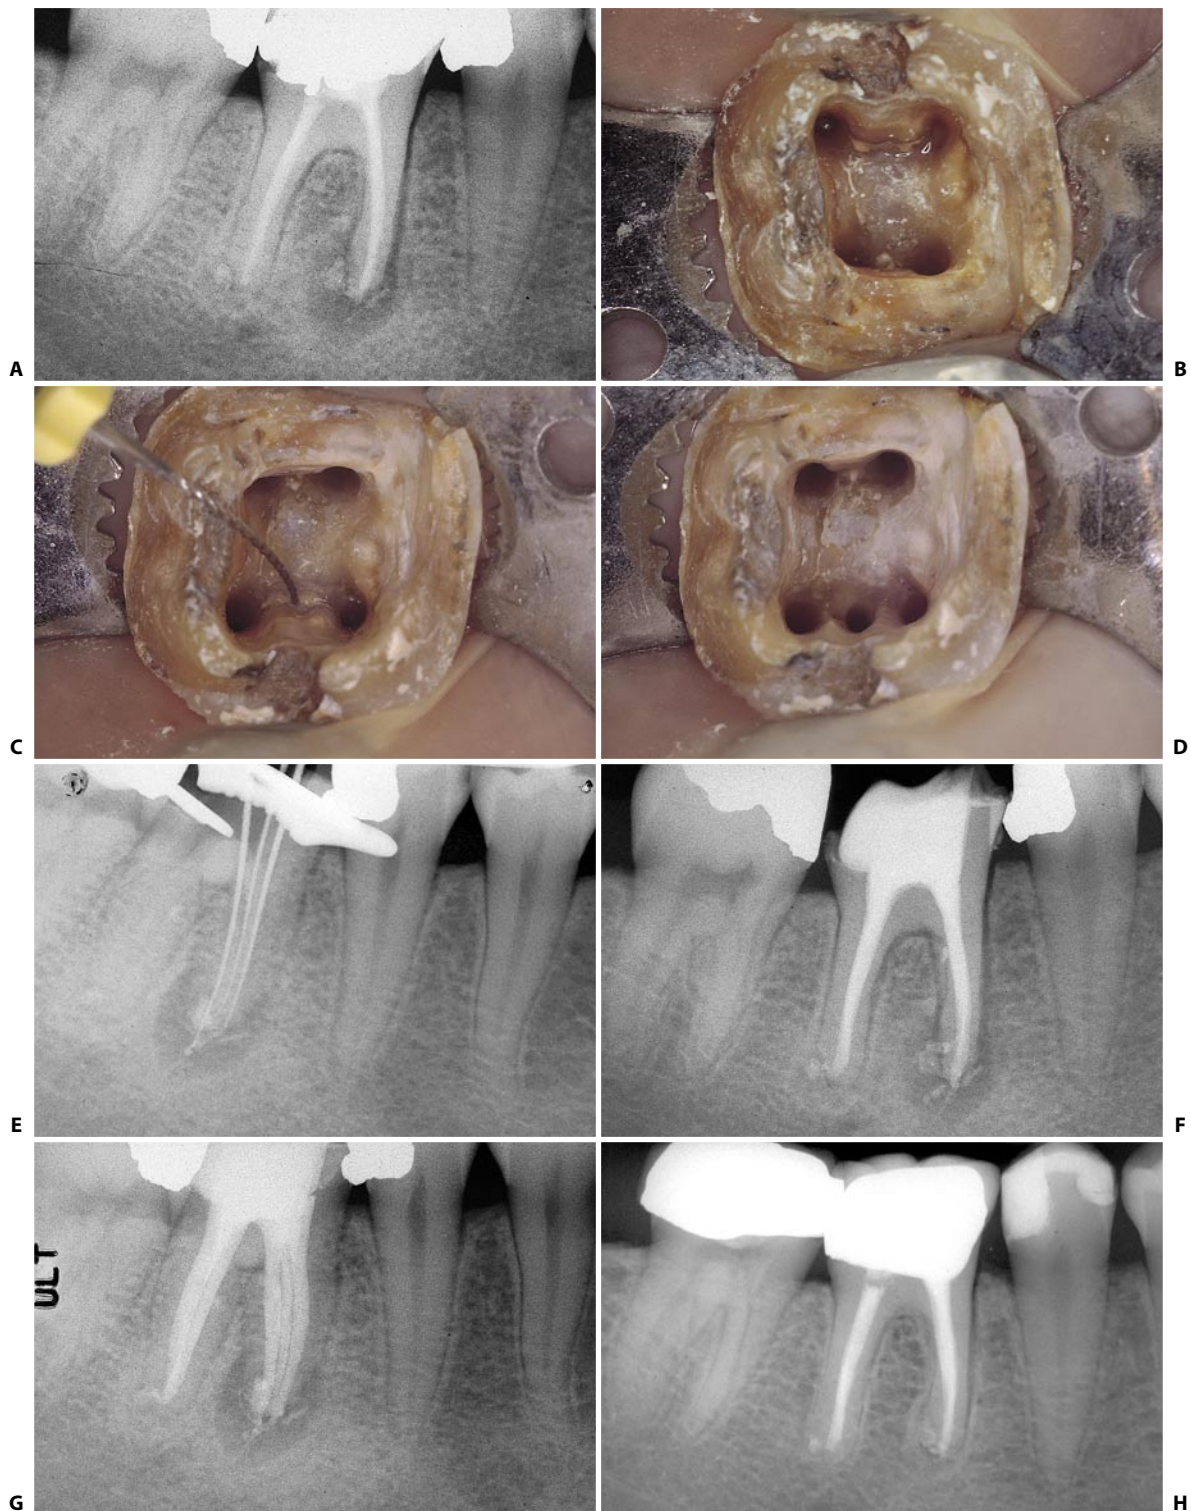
Retreatment of a lower right first molar, where two canals had been missed: the distobuccal and the middle mesial canals. A. Preoperative radiograph. B. Access cavity after four canals had been prepared. Note the presence of a little depression in the isthmus between the two mesial canals. C. A # 10 file introduced into the depression very easily enters the middle mesial root canal, which has an independent foramen. D. The access cavity after preparing the five existing root canals. E. Three files show the three independent mesial root canals. F. Postoperative radiograph. G. The off-angle radiograph shows the five canals. H. The seven year recall radiograph shows the complete healing of the lesion, which was not caused by the foreign material, but by bacteria left in the missed root canals!
